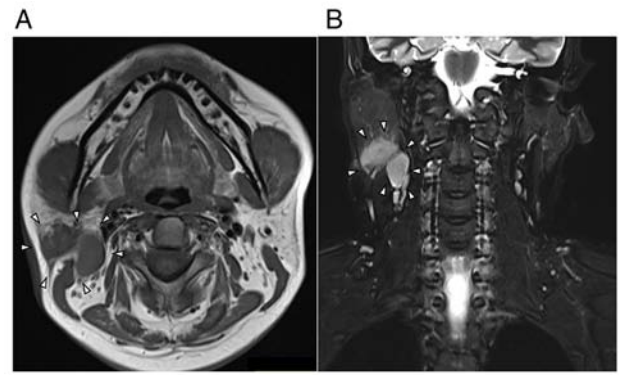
MRI showing a tumour in the right parotid gland. (A) T1-weighted MRI. (B) Short T1 inversion recovery MRI. Arrowheads indicate the tumour.
